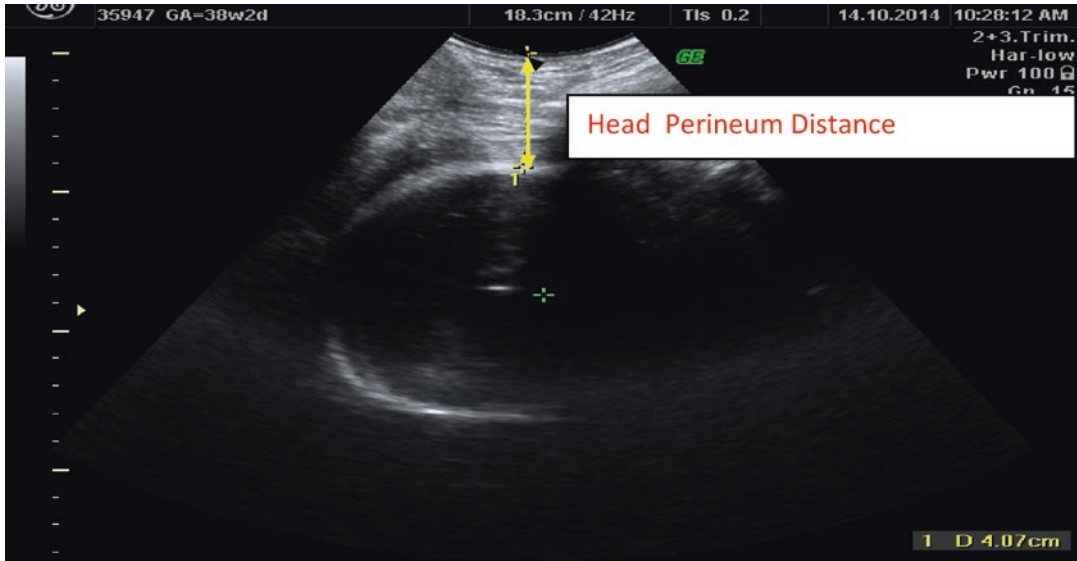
Head–perineum distance—transperineal ultrasound with probe in transverse direction, shortest distance between the skull and skin of the perineum
